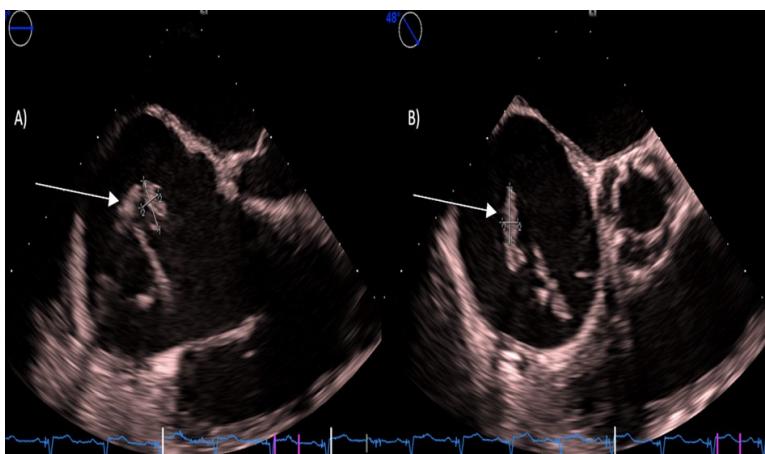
Images from transesophageal echocardiogram. A) Mid-esophageal, 4-chamber view, showing the mobile right atrial thrombus (arrow); B) Mid-esophageal, aortic valve short axis view, demonstrating vegetations (arrow) along the right ventricular lead.
